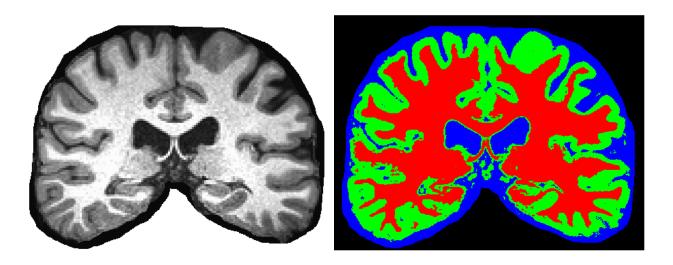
CRBM segmentation of a novel coronal MRI slice.
